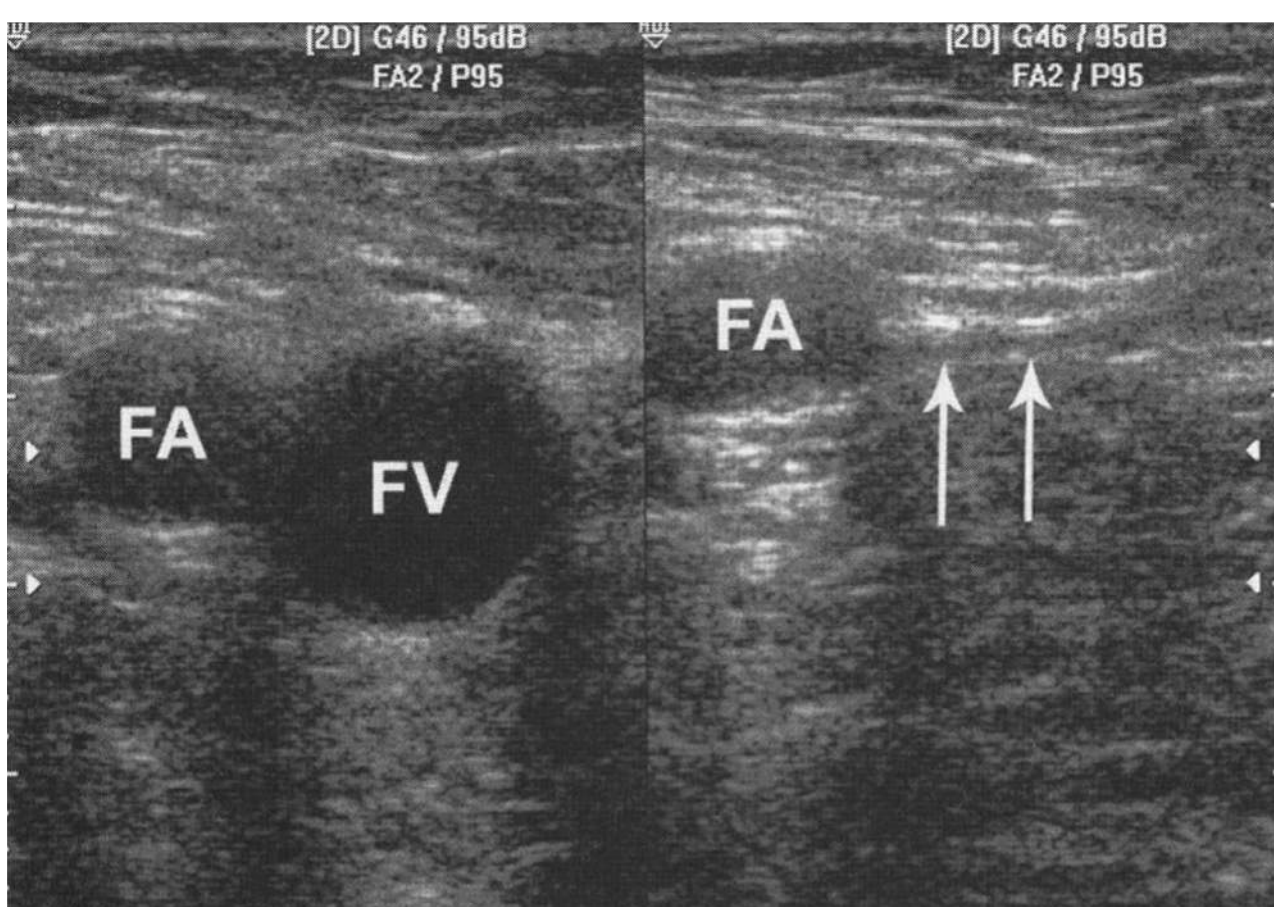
A split screen showing the common femoral artery (FA) and common femoral vein (FV). The left is without compression. The right is the view after pressure has been applied with the transducer causing the femoral vein to collapse with its wall barely visible (arrows). (Reproduced with permission from Ma OJ, Mateer, JR, & Blaivas M: *Emergency Ultrasound*, 2nd edition. New York: McGraw-Hill Publishing; 2007.)
